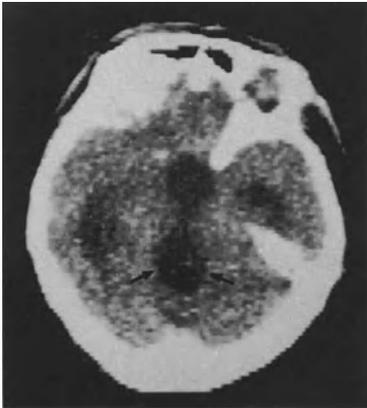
CT shows marked ventricular dilatation and a cystic lesion dorsal to the third ventricle (*black arrows*)
